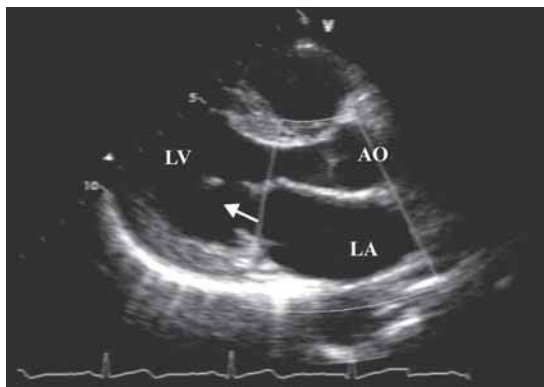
Stop frame during end diastole from a two-dimensional echocardiogram of a patient taken in the parasternal long axis. The moving column of blood (arrow) from the left atrium (LA) into the left ventricle (LV) is shown. Strong atrial contraction during this phase augments the ventricular filling, which could be decelerated abruptly if the ventricular compliance is reduced for any reason, producing an S4.
